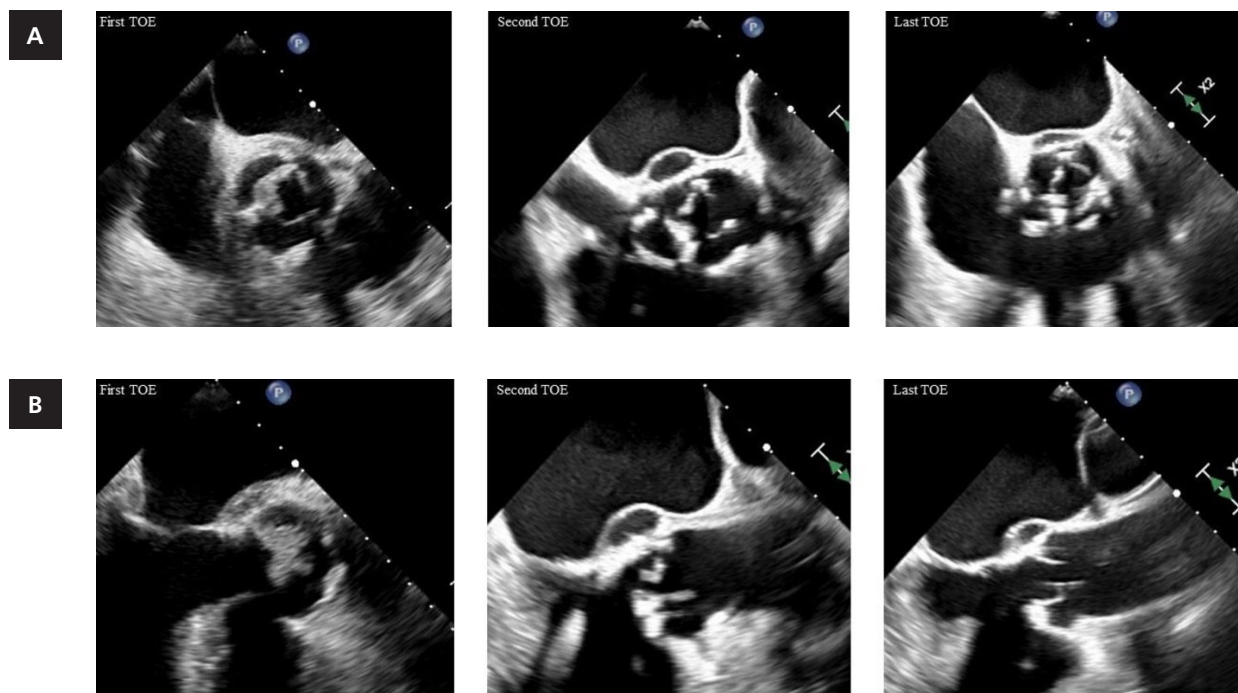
(A) Comparative transesophageal images: 45° aortic valve short-axis. (B) Comparative transesophageal images: 120° aortic valve long-axis.
